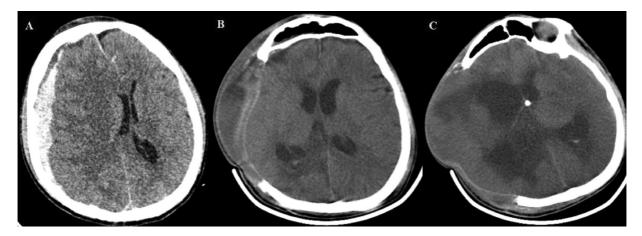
Meningitis with post-DC hydrocephalus. Noncontrast CT head showing (A) a large right FTP SDH with mass effect, a midline shift of 1.3 cm, and uncal herniation. (B) Postcraniectomy with the presence of hydrocephalus. (C) External cerebral herniation with hydrocephalus with left frontal external ventricular drainage in situ.
